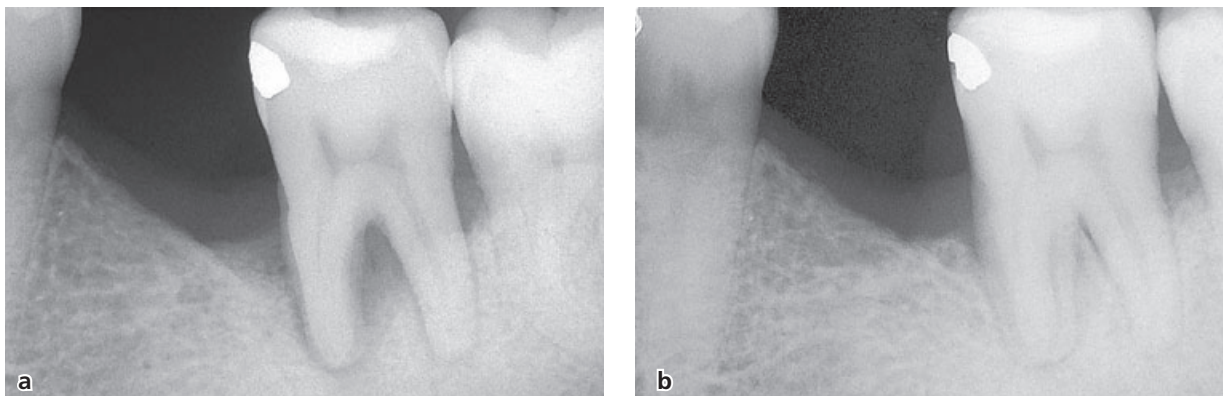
(a) Radiographic appearance of a defect in the furcation area caused by occlusal overload. After occlusal adjustment the interradicular defect spontaneously healed, as documented 6 months after therapy in a radiograph (b). (Courtesy of M. Cattabriga.)
